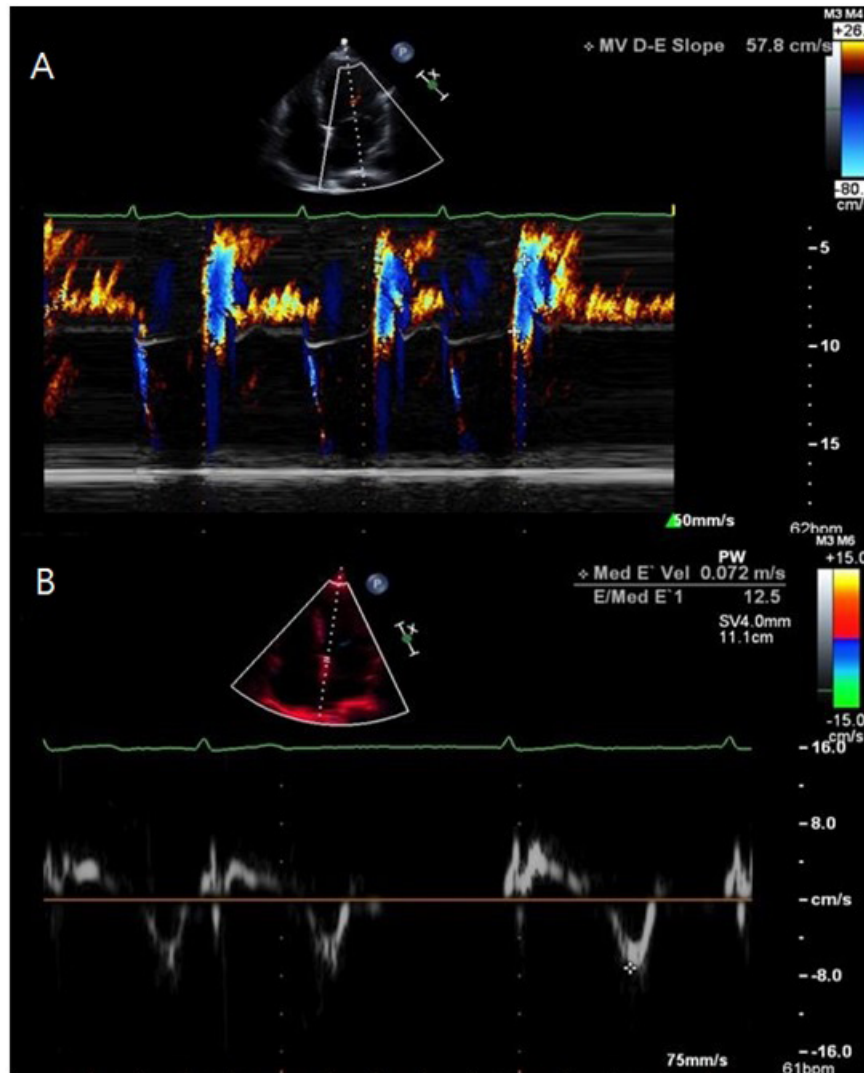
M-mode and tissue Doppler echocardiographic recording examples. (A) Regional wall motion abnormalities were assessed by a visual technique. The left atrium (LA) with left ventricular (LV) volume and LV ejection fraction (EF) were recorded by color M-mode echocardiogram. (B) E/e' ratio and E/A ratio were measured by two-dimensional color-coded tissue Doppler imaging.
